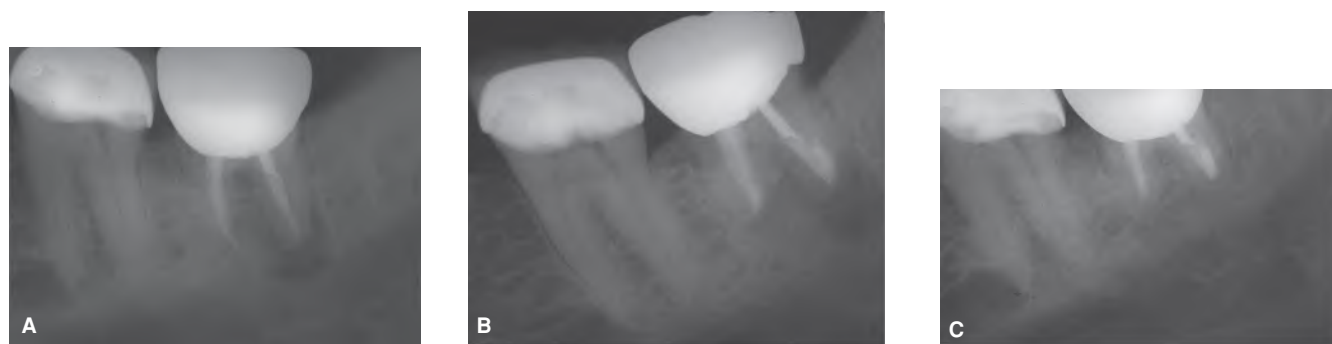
A. Preoperative radiograph of a second mandibular molar associated with symptomatic apical periodontitis. B. Postoperative radiograph of the tooth after replantation procedure. C. A follow-up radiograph two years after the procedure shows complete resolution of the periapical pathosis.
